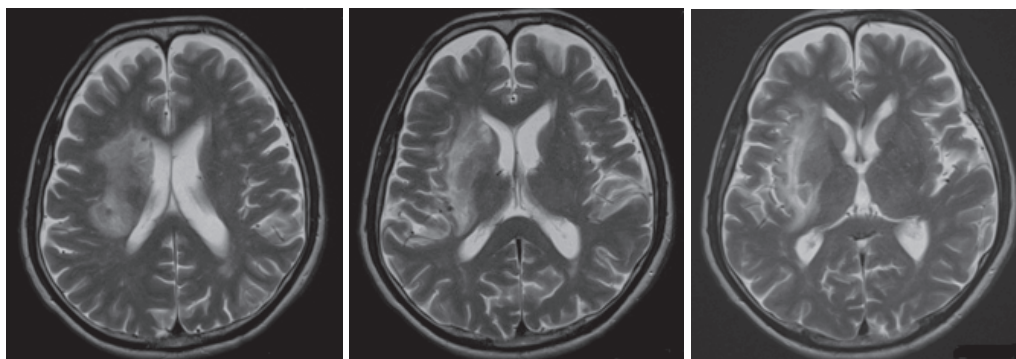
Head MRI performed 9 days after onset. T2-weighted images revealed a high-intensity area in the right middle cerebral artery region.
